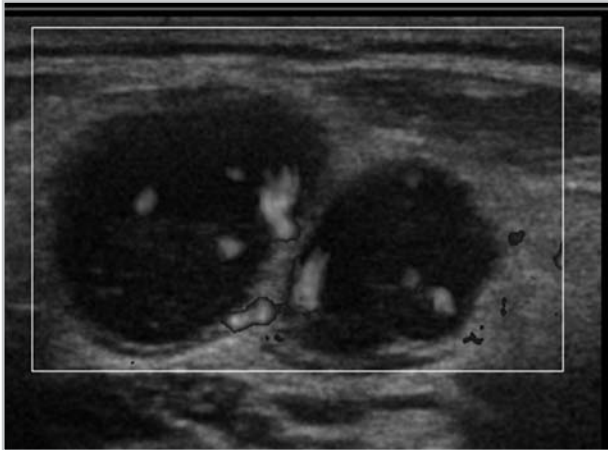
Color Doppler ultrasound shows enlarged abdominal nodes with increased vascularity.
